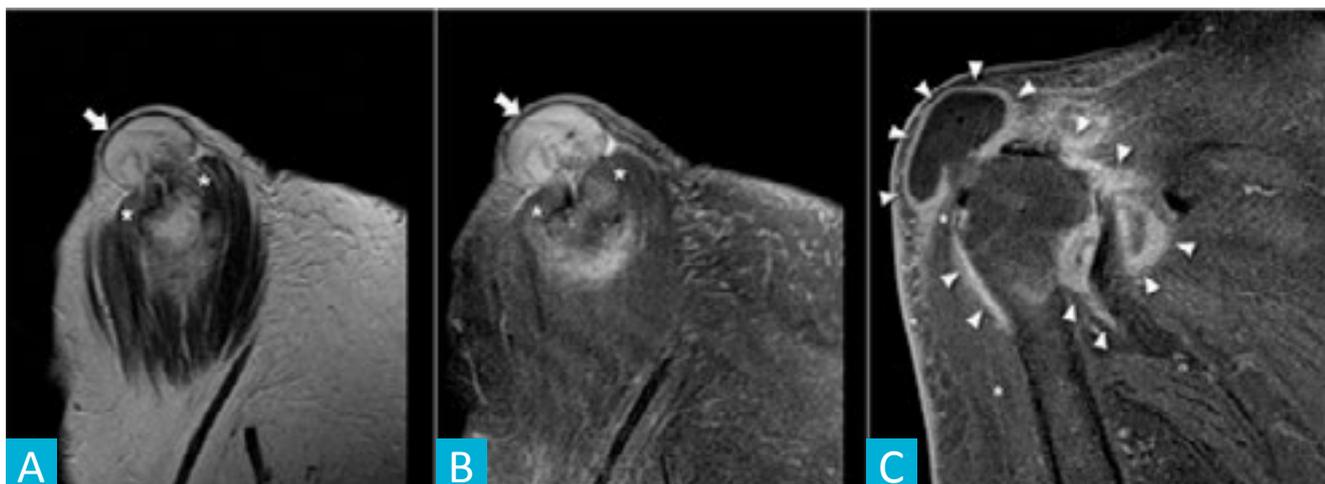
Pseudo-geyser. Sagittal T2w weighted (A) and sagittal T2w fat-saturated (B) MR images depicting the pseudo-geyser [arrow] protruding through a full thickness tear near the proximal insertion of the deltoid [asterisk]. Coronal T1w fat-saturated MR image after intravenous administration of gadolinium (C) showing the hyper-enhancement of the pseudo-geyser wall and the articular capsule, corresponding to the inflammatory/ infectious reaction.
